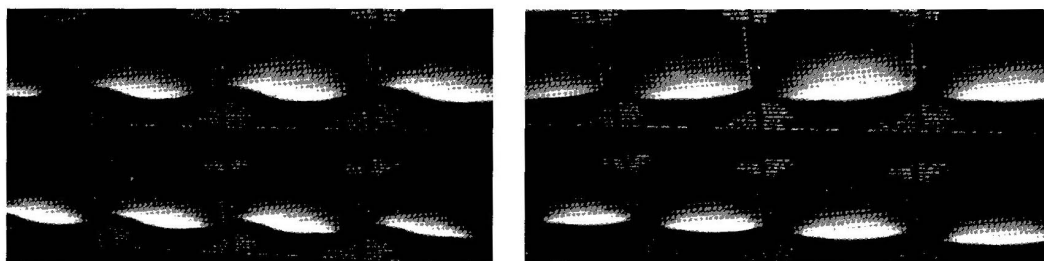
Axial plane T1-weighted pre and post-treatment images of patient 1.
